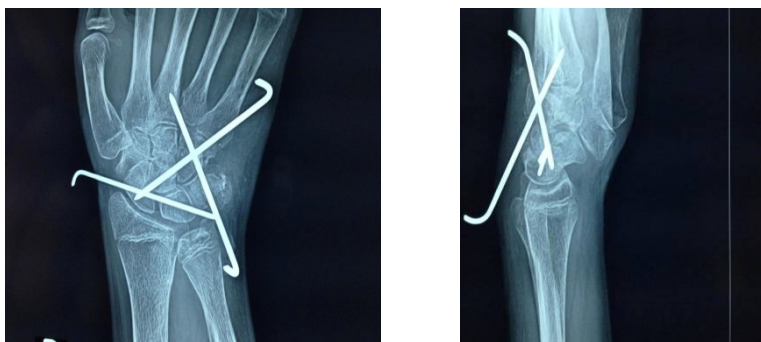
Plain radiographs 2 days after surgery, AP and lateral views show the carpal reduction and transfixations.
